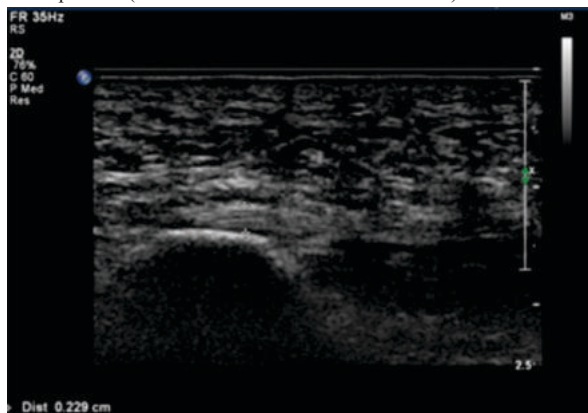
Ultrasound Of Normal Plantar Fascia.
